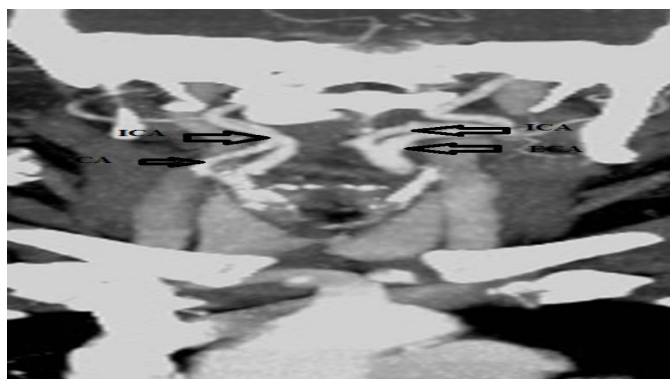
CT post contrast coronal reformatted image showing right and left external carotid artery (ECA) and internal carotid artery ICA. Note the medial deviation of the carotid vessels.
